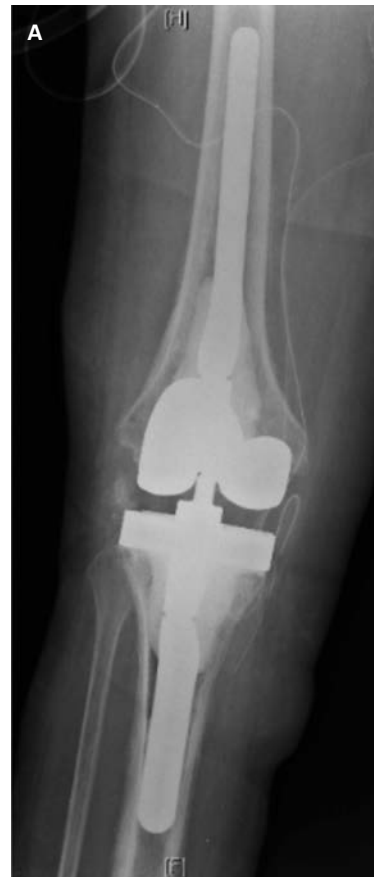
AP (A) and lateral (B) postoperative radiographs of a patient undergoing revision TKA with press fit femoral and tibial stems and cemented metaphyseal components.
